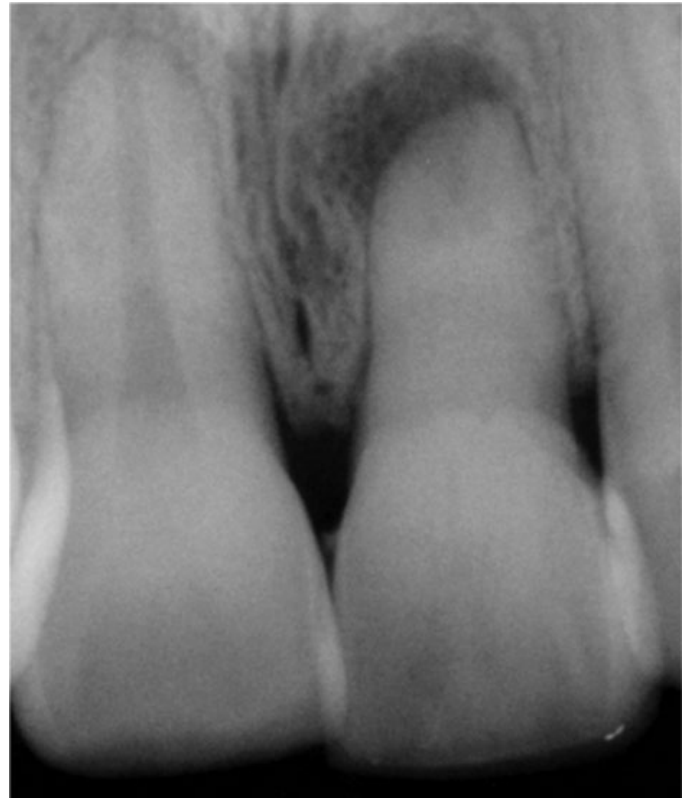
(B) Radiograph of a similar maxillary central incisor 10 years after a concussion injury. The pulp chamber is filled in with dentin producing the discoloration. In this case, there was pulp death after discoloration appeared. Because the pulp canal was obliterated, a surgical approach was used to seal the apex.
